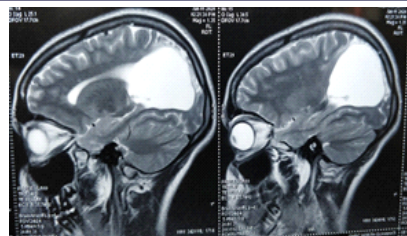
T2 Sagittal MRI Sequence showing cystic cavity present in left Parieto-occipital region communicating with the left lateral ventricle.
